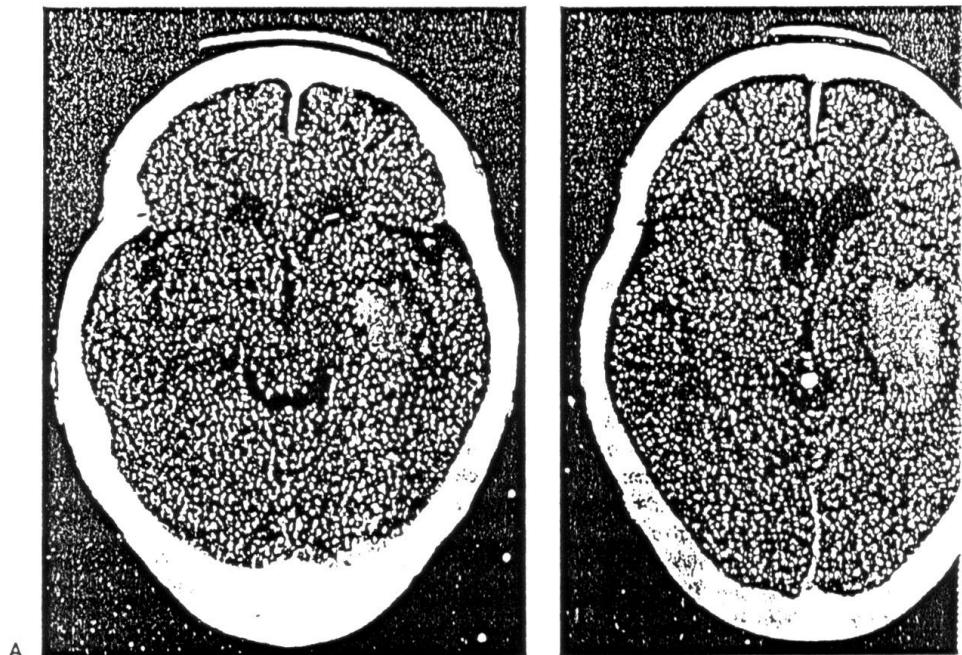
CT scan in a 92-year-old man with a putaminal (hypertensive) hemorrhage. Note sulci and fissures. Despite large volume of hemorrhage, no shift is seen and the additional pressure is well-tolerated.
